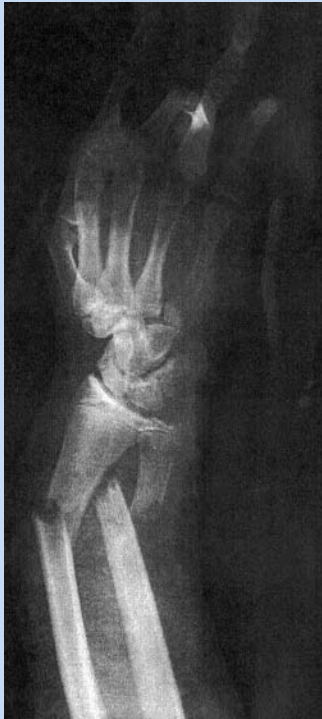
Gymnast B's anteroposterior radiograph of radius and ulna fractures at the time of injury.
